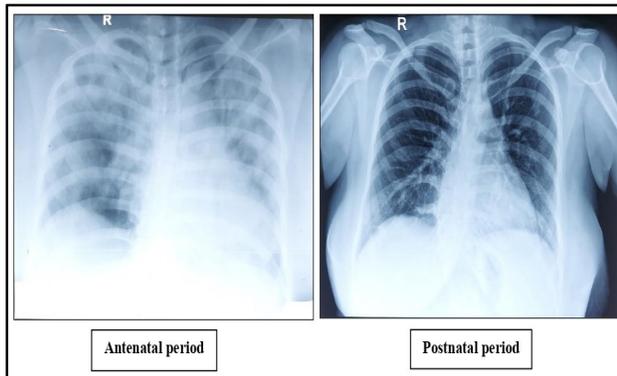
Comparative chest radiograph showing bilateral widespread consolidation/ opacities with severe ARDS (during the antenatal period) and fine fibrotic changes (during the postnatal period).
